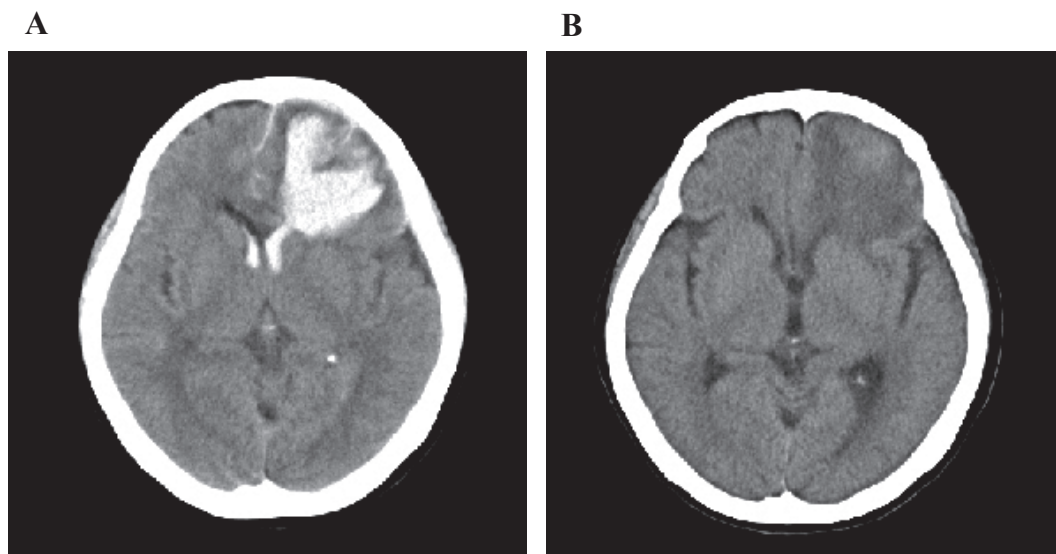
Head computed tomography (A) Left frontal subcortical hemorrhage with ventricular perforation, (B) one month later
